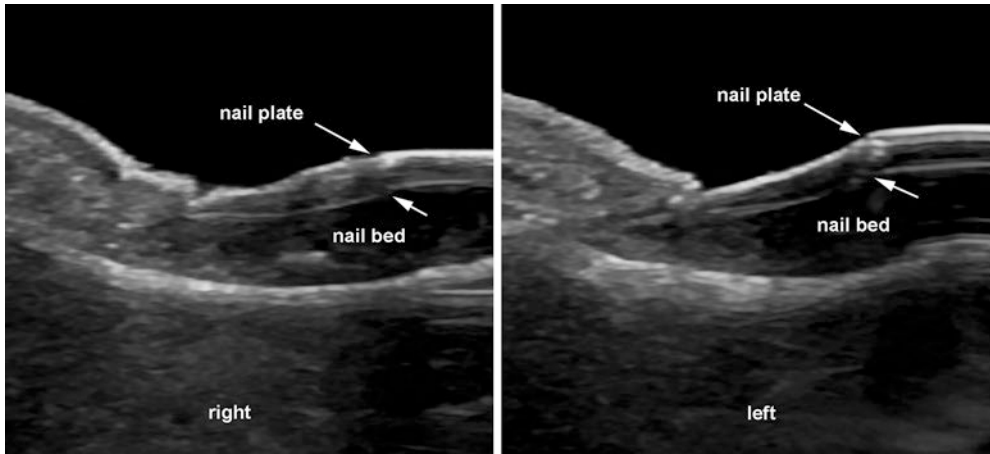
Onychomadesis. Grayscale ultrasound (comparative side-by-side; longitudinal views; big toes) shows fragmentation of the nail bed at both sides, slightly more
